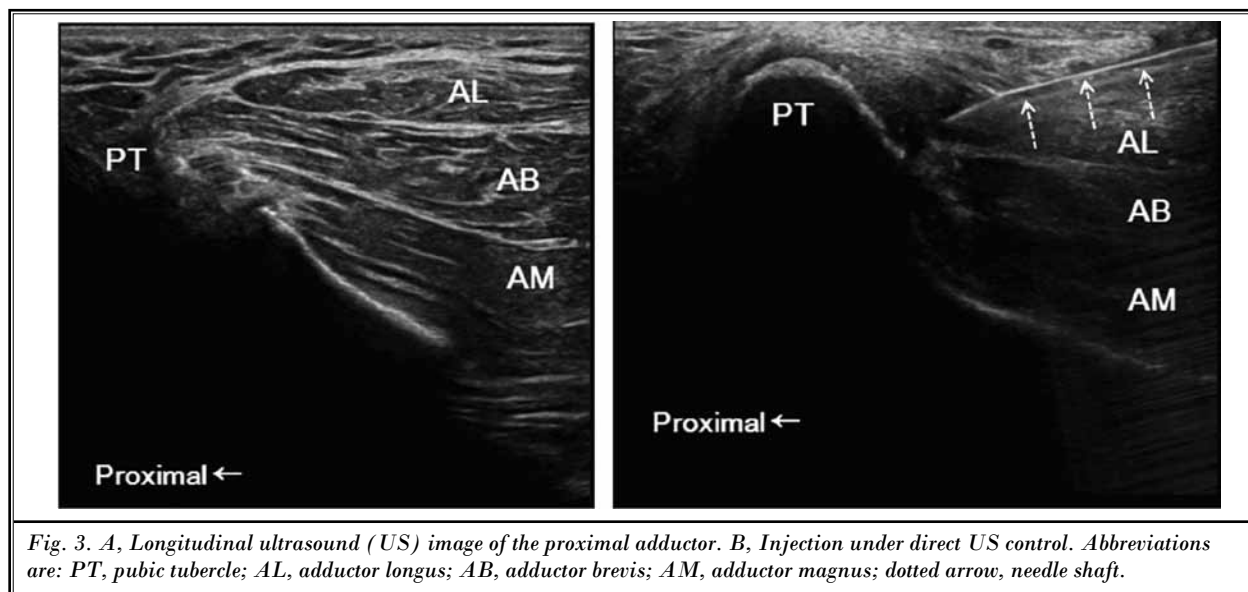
A, Longitudinal ultrasound (US) image of the proximal adductor. B, Injection under direct US control. Abbreviations are: PT, pubic tubercle; AL, adductor longus; AB, adductor brevis; AM, adductor magnus; dotted arrow, needle shaft.
